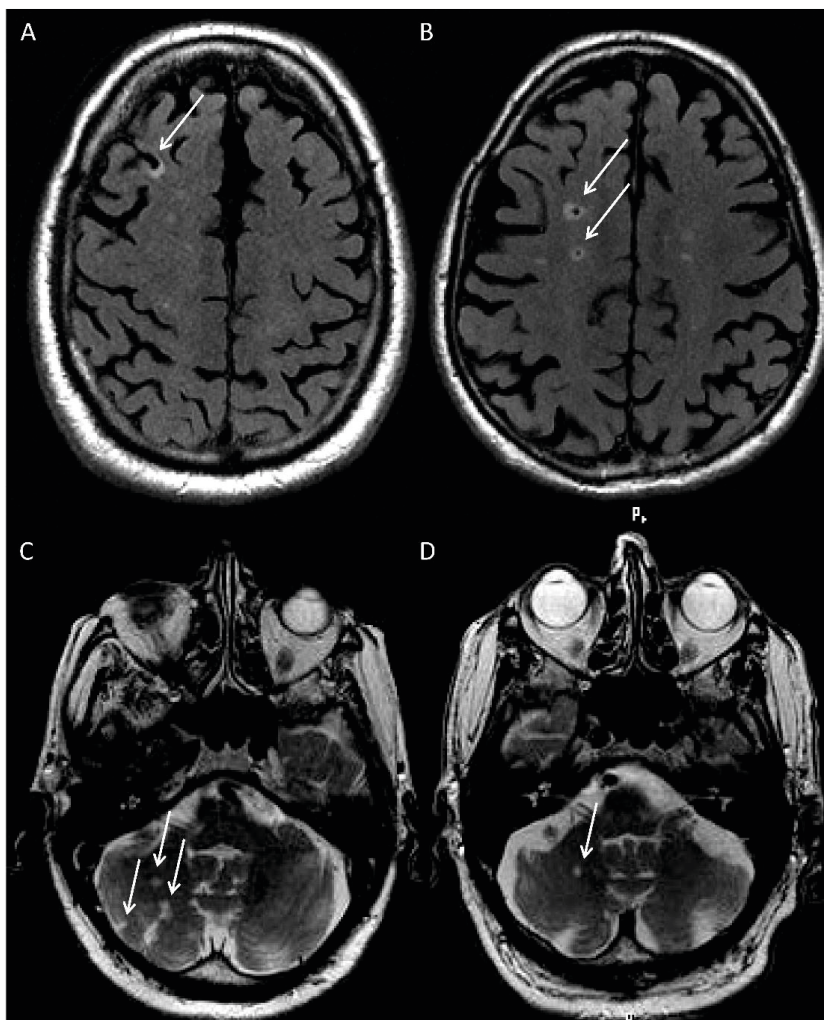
Example images of infarcts in subregions. A, Cortical infarct in the right frontal lobe on a fluid-attenuated inversion recovery (FLAIR) image. B, Subcortical infarcts on a FLAIR image in the right frontal lobe. C and D, Cerebellar infarcts on a T2-weighted image.
